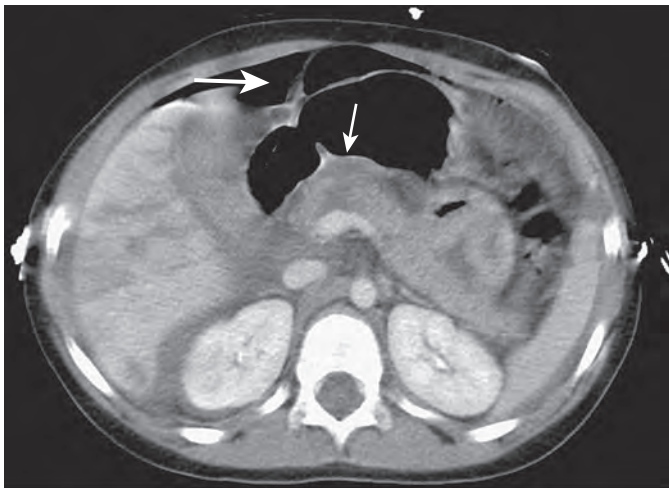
Pancreatic contusion. The CT scan through the upper abdomen of a 3-year-old boy after a motor vehicle accident shows focal low attenuation in the pancreatic head in the typical distribution anterior to the spine (small arrow). The patient also has free intraperitoneal air from a duodenal laceration (large arrow).
